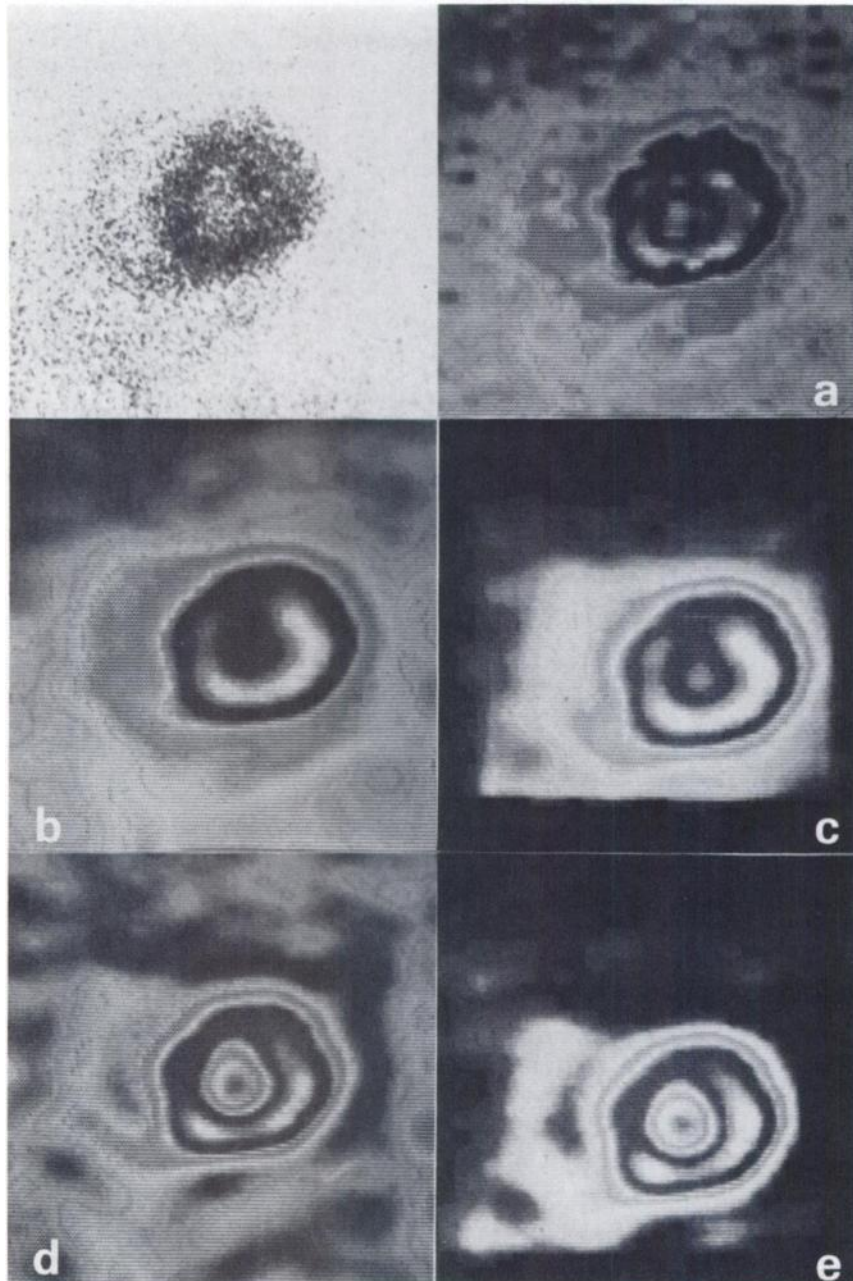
Myocardial Tl-201 scintigraphy of normal subject in LAO view at 45°. (Ana) Analog, (a) digitalization, (b) binomial smoothing, (c) background subtraction by linear interpolation, (d) Canterbury filtering, (e) 'c' followed by 'd' filtering.
